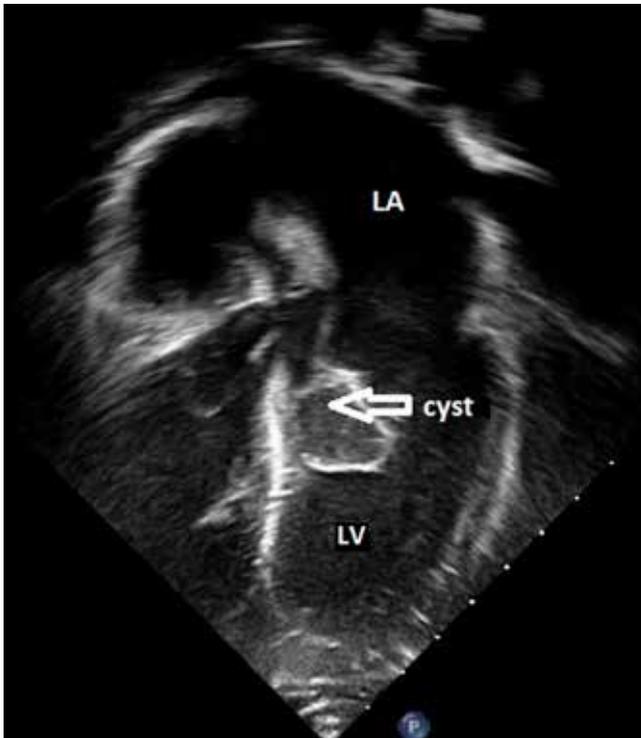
Transthoracic echocardiogram – apical 5 chamber view. “Balloon”-like cyst (white arrow) attached to the anterior mitral leaflet
